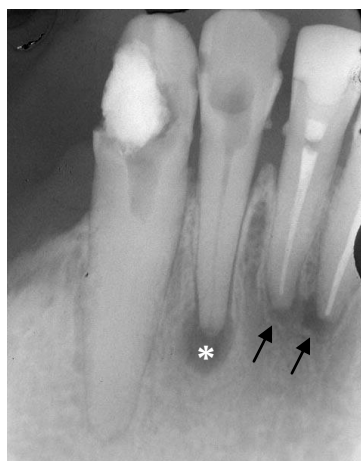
Periapical lesions (*) in a pulp compromised tooth and endodontically treated teeth (arrows).
